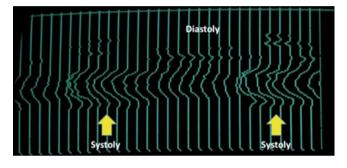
Flow profile (pulsed multigated Doppler) from carotid bifurcation showing flow separation (*arrows*) during systole. Note flow is retrograde (right shift) along the far wall of the artery during systole
